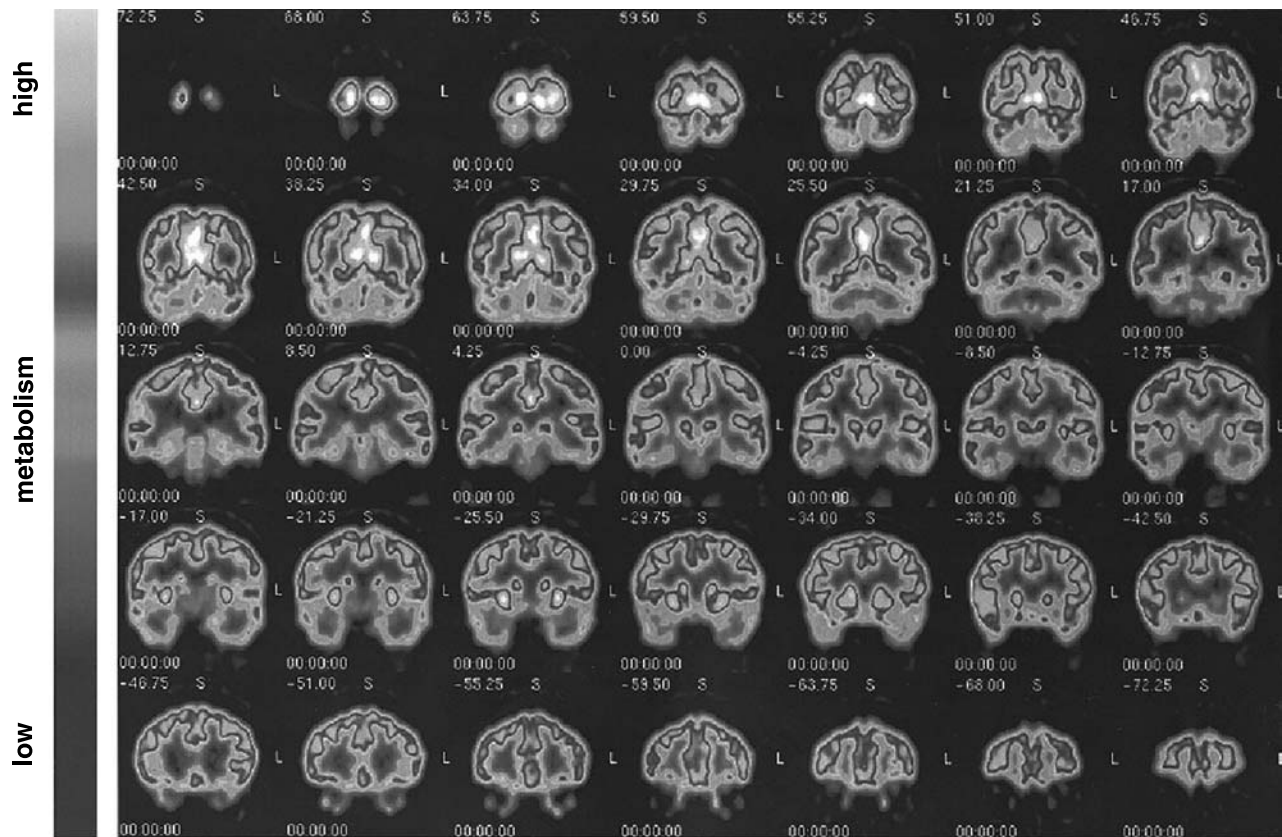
18F-FDG-PET 20 months after gamma knife surgery scan detected no significant asymmetries and specifically no regions of asymmetrical hypometabolism in the temporal lobes as would be typical for radio necrosis. Low metabolism is coded by dark blue to black colors as indicated by the color bar on the left
